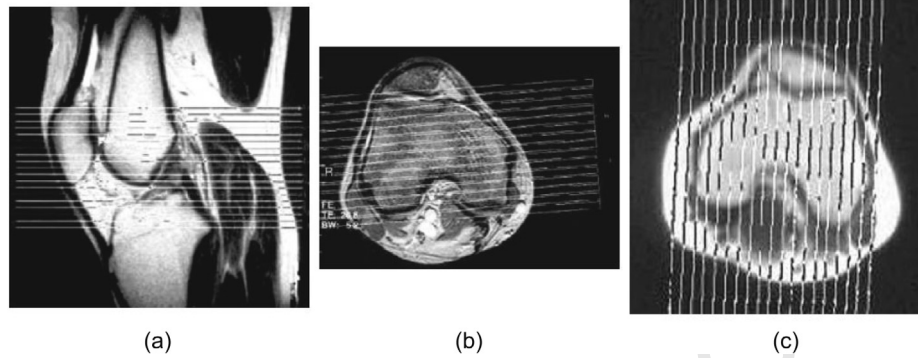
MRI of the knee joint – a pilot study in the planes: (a) transverse, (b) coronal, and (c) sagittal [4].
